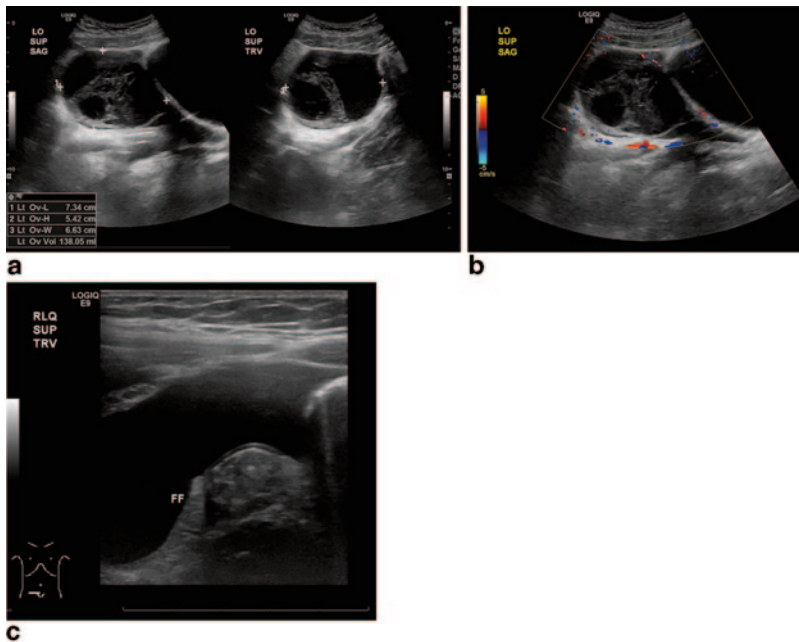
a and b An 11-year-old female with midcycle left lower quadrant pain found to have enlarged, echogenic left ovary lacking internal Doppler flow. Initially
